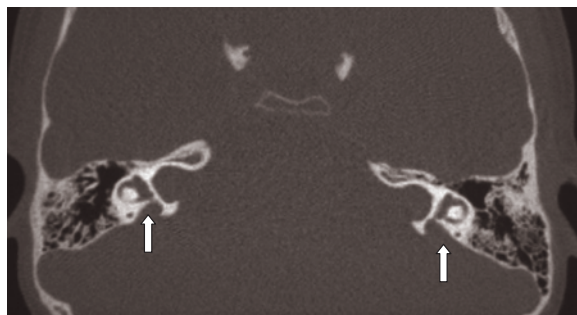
CT scan showing widened vestibular aqueducts.
